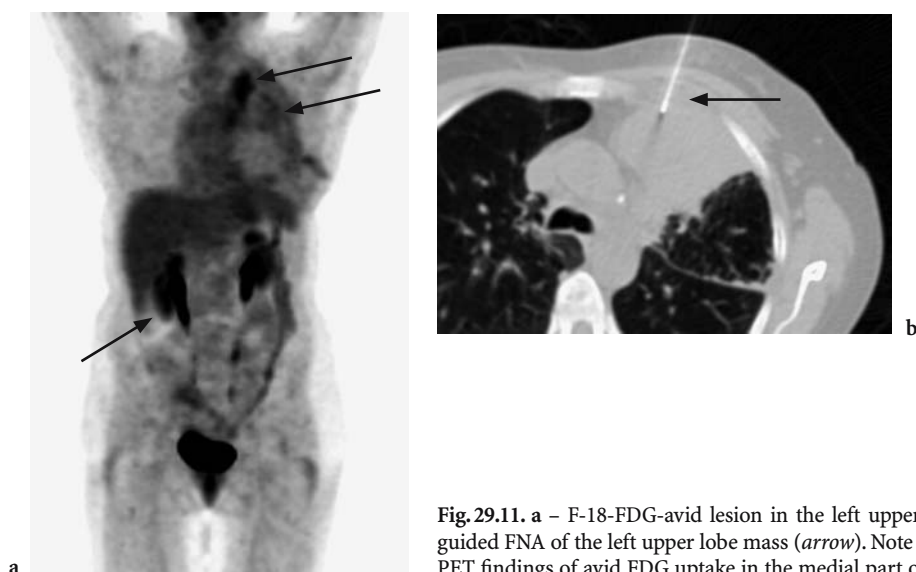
a – F-18-FDG-avid lesion in the left upper lobe on PET (arrows). b – CT-guided FNA of the left upper lobe mass (arrow). Note that FNA biopsy is guided by the PET findings of avid FDG uptake in the medial part of the large left upper lobe lesion
